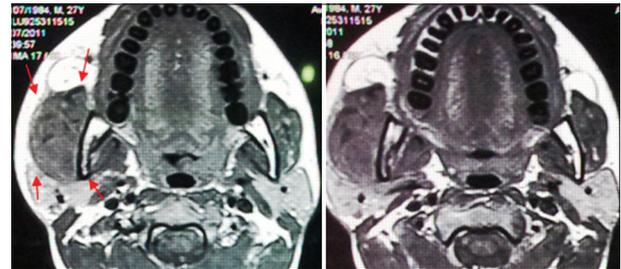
Magnetic resonance imaging image of the head showing the abscess cavity and the area of destruction on the right side of the face
